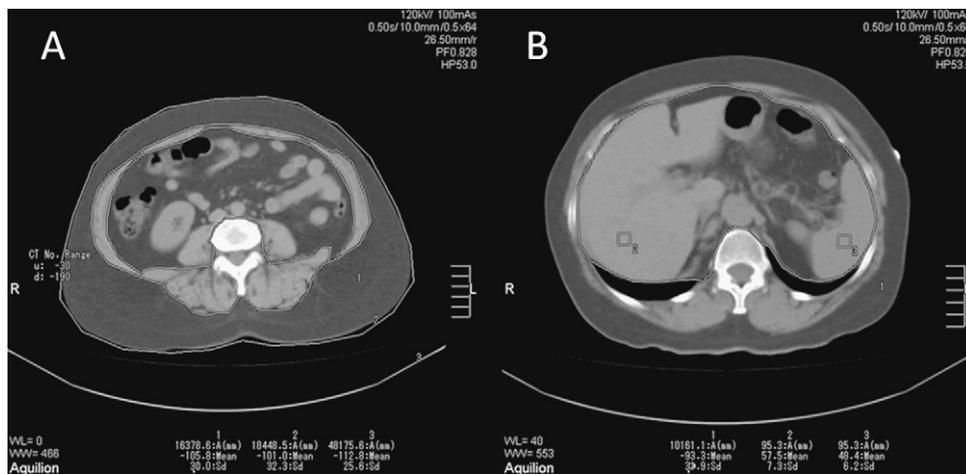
Computed tomography in L4–L5 (A) and T12–L1 (B) intervertebral levels to assess visceral adiposity. (A) The visceral fat area (VFA) (1), the muscular and VFA summed (2) and the total fat areas in mm^2 (3) are manually determined at L4–L5 level. The subcutaneous fat area is determined subtracting the total fat area from the muscular summed VFA. These measurements represent the umbilicus topography. (B) The VFA (1) is manually determined at T12–L1 level and two regions of interest are located at the liver (2) and at the spleen (3) to determine the attenuation ratio between them. These measurements represent the VFA in the liver topography.
